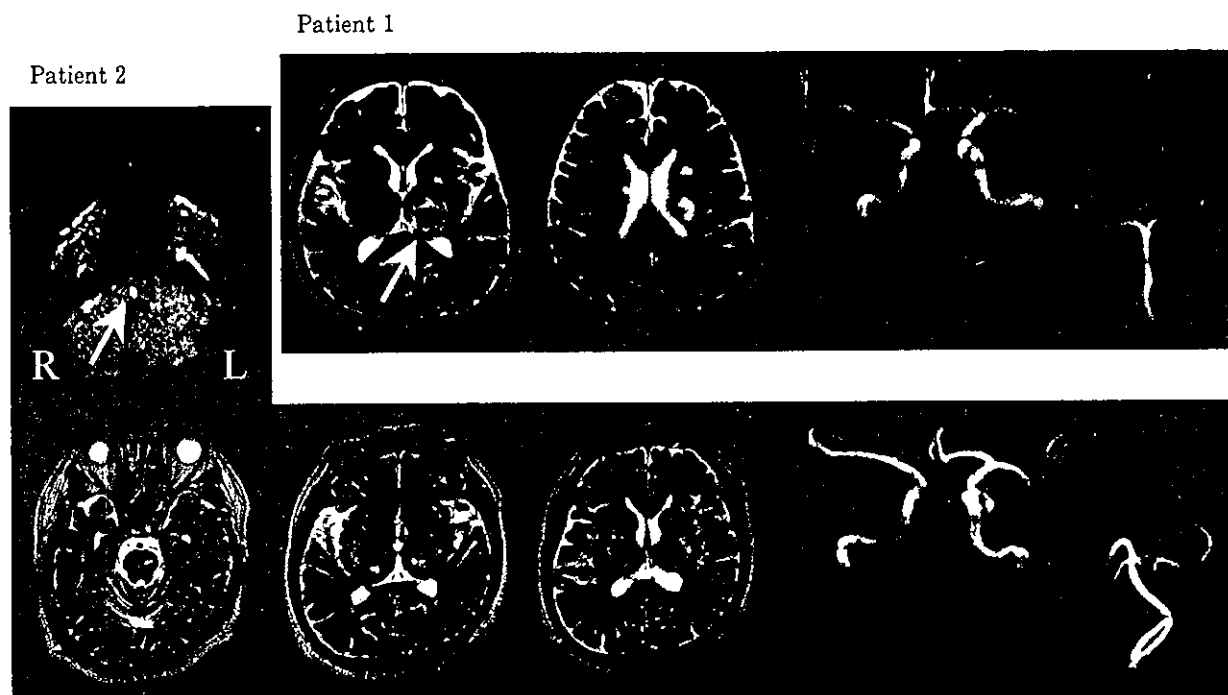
Cranial MRI and MRA on admission following the final stroke. T2-weighted image reveals a left thalamic hematoma in Patient 1 (arrow). Diffusion-weighted image reveals a fresh infarct in the right tegmentum of the pons in Patient 2 (arrow).
